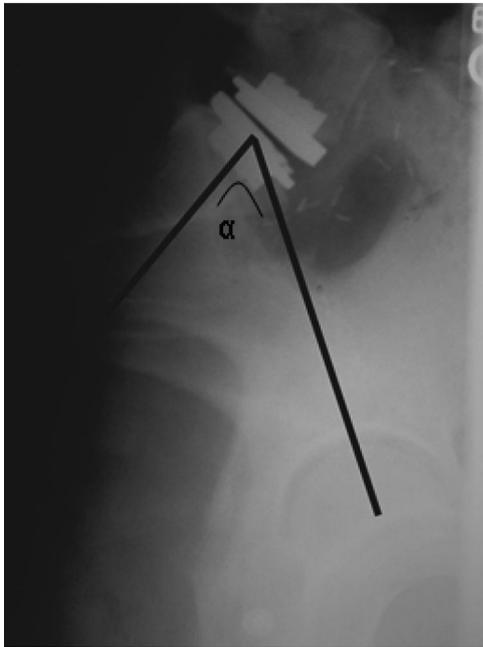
Pelvic inclination (PI) measurement. PI had no effect on clinical or radiographic outcomes.
